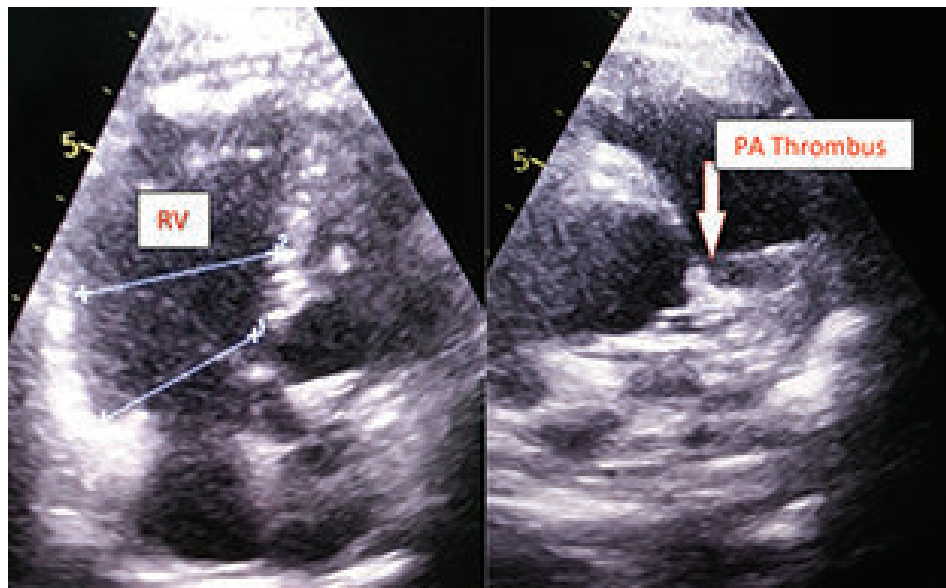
Trans thoracic echocardiogram RV focused and short axis view of PA showing dilated RV and thrombus.
